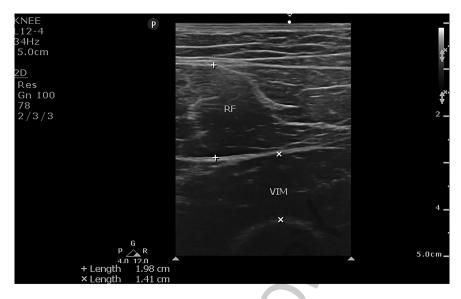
Measurement of quadriceps thickness of hyaluronic acid injected under ultrasonographic image in short axis. Ultrasonographic probe was placed transversely at the midpoint between anterior superior iliac spine and the upper pole of the patella when patients' legs in full extension. The thickest parts of vastus intermedius and rectus femoris muscles were measured and summed. Two measurements were made and the mean was recorded (RF, rectus femoris muscle; VIM = vastus intermedius muscle).
